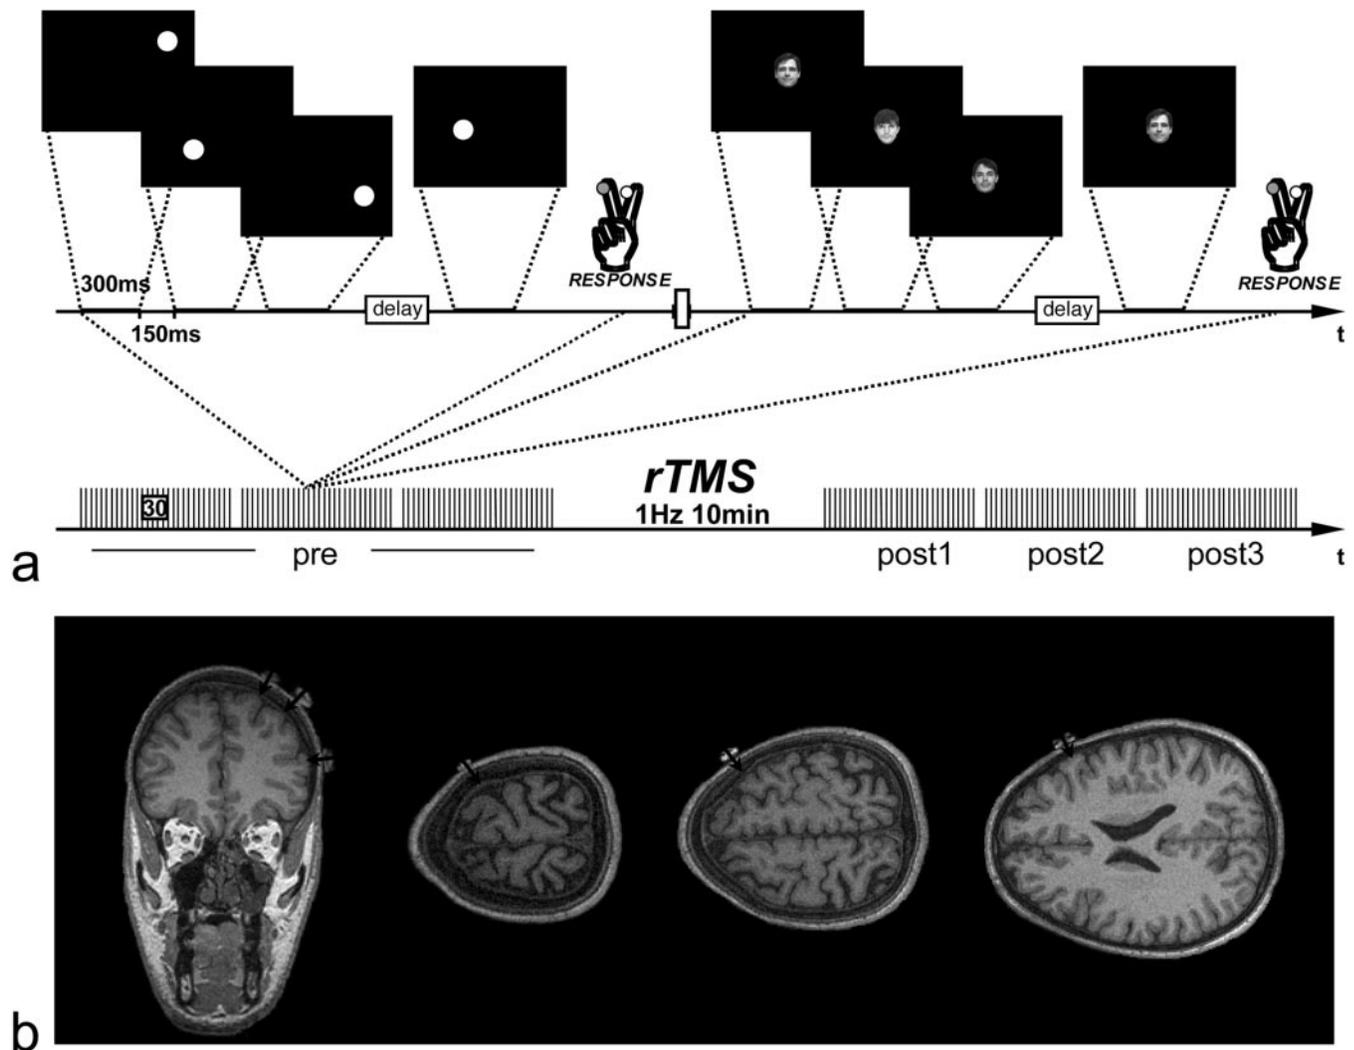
(a) In the first row the design of the delayed working memory task for spatial or face stimuli is shown. The delay period between the set of three stimuli, which were consecutively presented (300 ms each with an ISI of 150 ms), and the target stimuli was randomized between 2, 3 or 4 s. Subjects had to respond with the index ('no') or middle ('yes') finger pressing two different keys, deciding whether the target stimulus was within the set of the previously presented stimuli or not. In the second row the experimental set up is sketched (details in the text). (b) Positioning of the coil over the left DMPFC (Dm) DLPFC (DI) and VPFC (V) was confirmed using a 3-D MRI sequence with vitamin E capsules in place.
